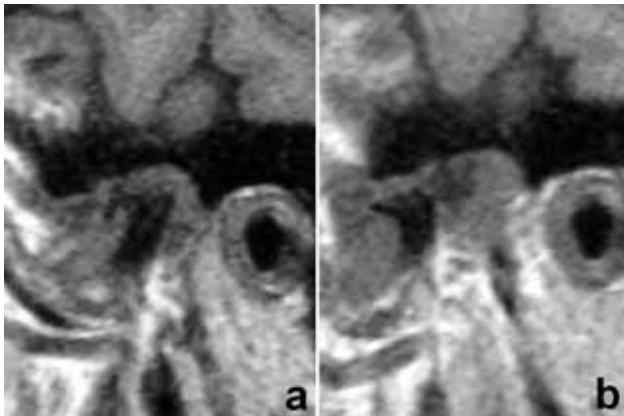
MRI of the left TMJ prior to splint treatment: closed mouth position (a) open mouth position (b)
